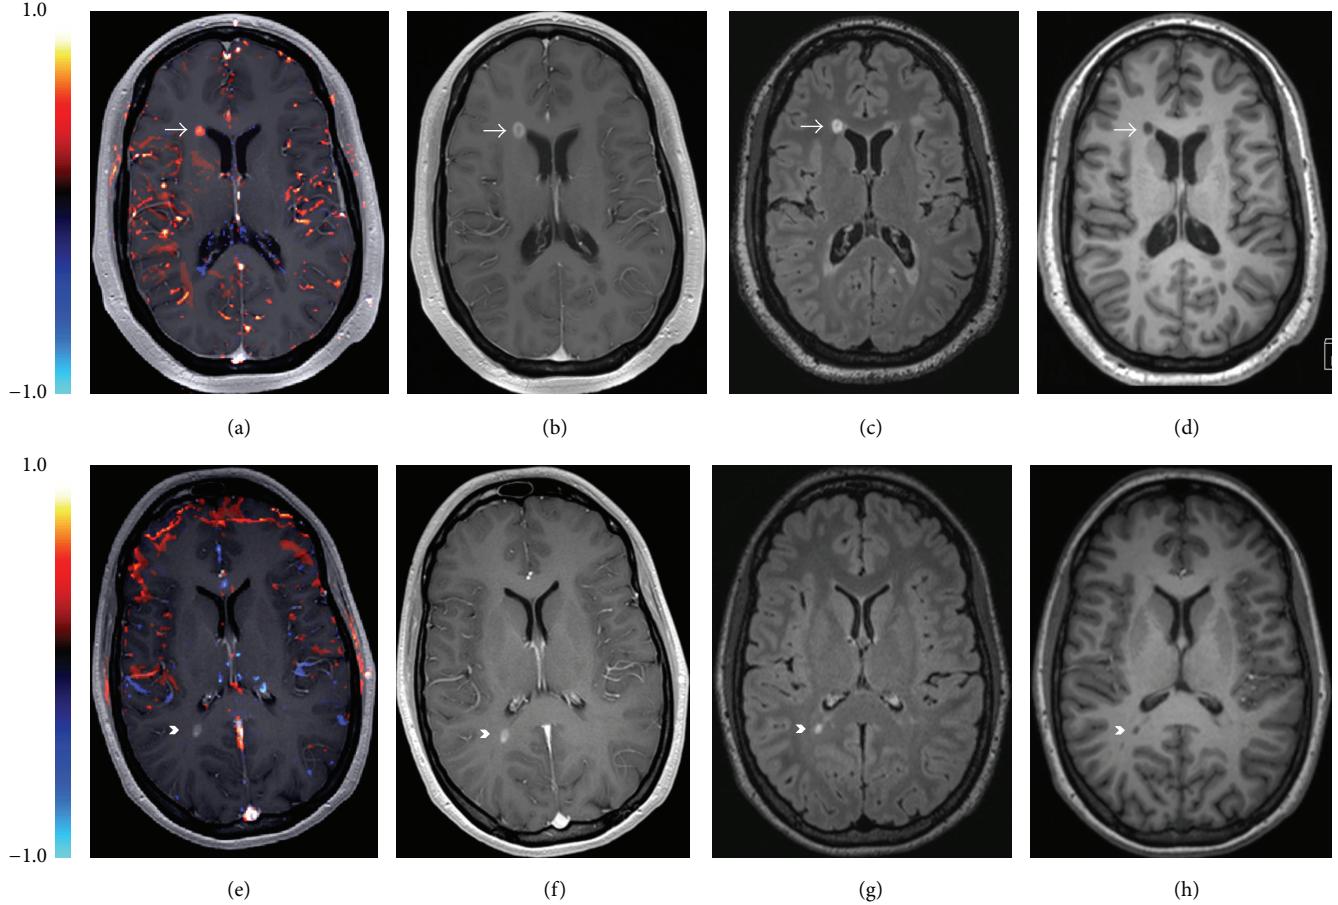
Prestratification of demyelinating lesions according to their leakiness. The upper row shows an enhancing lesion classified as EL+ (arrow), (a) T1w post-Gd after postprocessing with NORDIC Ice: the red area reflects the lesion with high permeability above the predefined cutoff value of 0.01; (b) T1w post-Gd; (c) FLAIR sequence; (d) T1w pre-Gd. The lower row shows an enhancing lesion classified as EL- (arrowhead); (e) T1w post-Gd, after postprocessing with NORDIC Ice: the lesion was classified as low permeability lesion below the predefined cutoff value of 0.01; (f) T1w post-Gd; (g) FLAIR sequence; (h) T1w pre-Gd.
